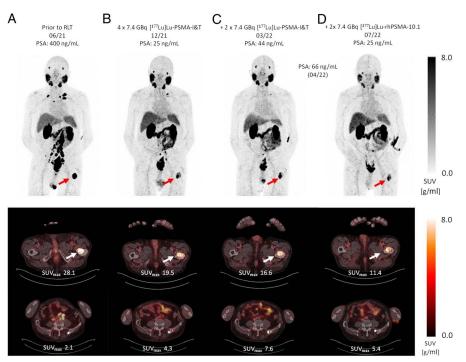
An 86-year-old man with metastastic castrate-resistant prostate cancer (mCRPC) and biochemical progression was referred for further theranostic workup. Previously, he had undergone androgen deprivation therapy including LHRH agonists (buserelin) and novel androgen axis drugs (enzalutamide) as well as taxane-based chemotherapy (docetaxel and cabazitaxel). PET/CT using ⁶⁸Ga-PSMA-I&T^{1,2} revealed local recurrence as well as multiple (pelvic, retroperitoneal, supraclavicular) lymph node and bone (eg, left femur, arrows) metastases (A). Subsequently, PSMA-directed radioligand therapy was recommended according to recent practice^{3,4} and the decision of the institutional interdisciplinary tumor conference. After 4 cycles with Lu-PSMA-I&T (B), a biochemical as well as radiologic partial response was noted. Treatment was continued for another cycles of the contrast to the continued response in the local as well as the lymphonodal tumor manifestations, increasing PSMA expression of metastases in the left femur (arrows) and left iliac wing (stars) as well as a new lesion in lumbar evertebra 5 was recorded, consistent with rising PSA serum values (C). Given the lack of further therapeutic options, 2 additional cycles of radioligand therapy with ¹⁷⁷Lu-rhPSMA-10.1 were offered on a compassionate use basis resulting in a renewed tumor response (D). Radiohybrid prostate-specific membrane antigen (rhPSMA) ligands are a new class of radiopharmaceuticals in prostate cancer theranostics. ⁵⁻⁷ Pretherapeutic dosimetry with one agent from this class (¹⁷⁷Lu-rhPSMA-7.3C) has recently shown (on an intrapatient basis) tumor uptake to be approximately 2.5 times higher than with ¹⁷⁷Lu-rhPSMA-18.T. Building on this observation, ¹⁷⁷Lu-rhPSMA-7.3C has been optimized in terms of pharmacological and pharmacokinetic properties yielding ¹⁷⁷Lu-rhPSMA-10.1 that is now being investigated in clinical trials (NCT05413850).
